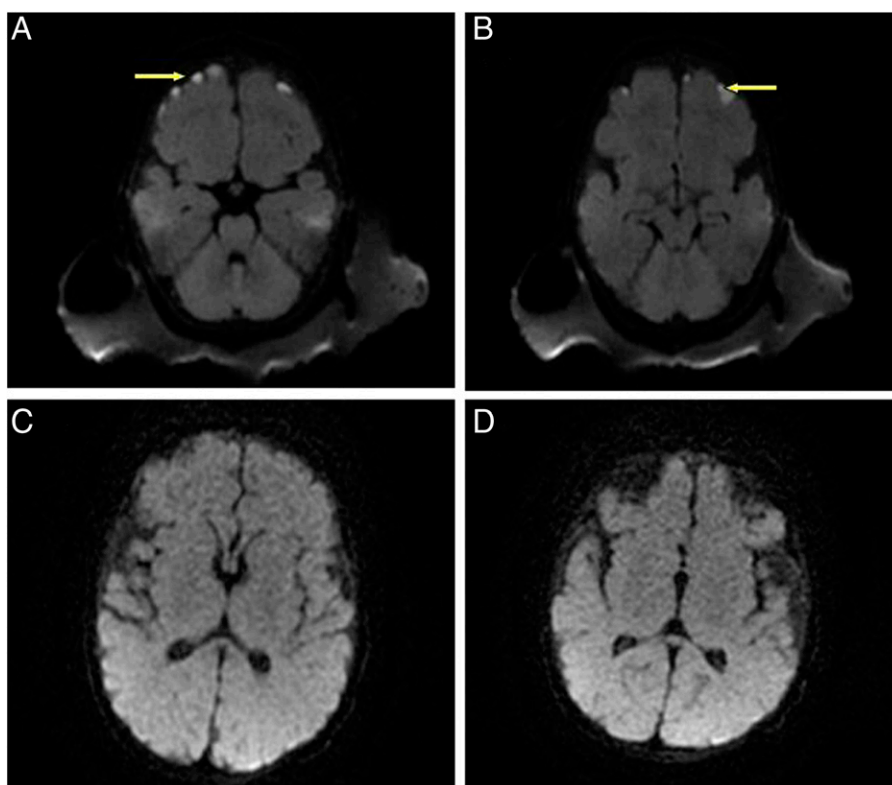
Magnetic resonance imaging of the brain. A and B. Multifocal small diffusion restriction (yellow arrows) along the frontal and parietal convexity is more prompt on the right side, raising the possibility of subdural empyema. C and D. The restriction disappeared after treatment.
